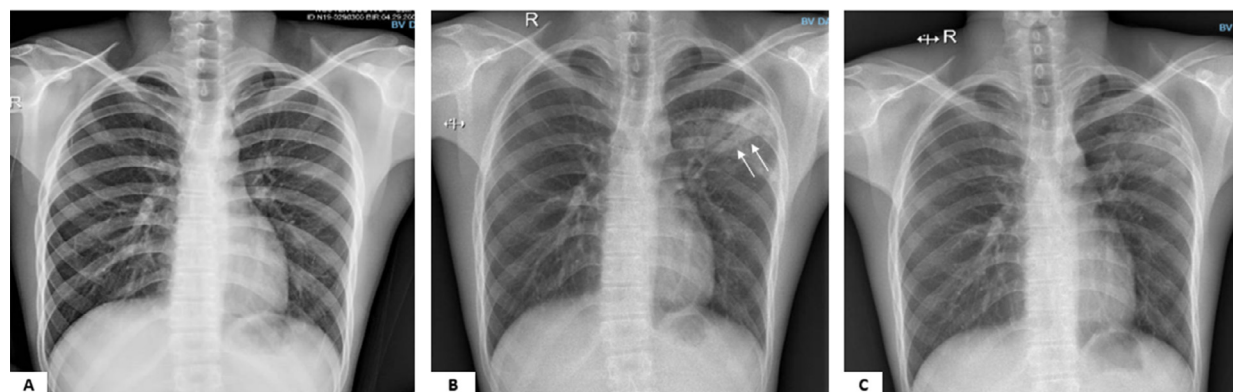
Chest X-ray. (A) Normal chest X-ray before secukinumab treatment. (B) Chest X-ray performed after 2 years of secukinumab therapy showed consolidation in the left upper lobe (long white arrows). (C) Chest X-ray after 4 months of anti-TB therapy showed that consolidation was reduced significantly.
